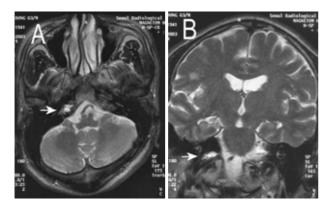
Brain MRI. This shows high signal intensity (arrow) in right petrous apex on T2 weighted axial (A) and coronal images (B).
